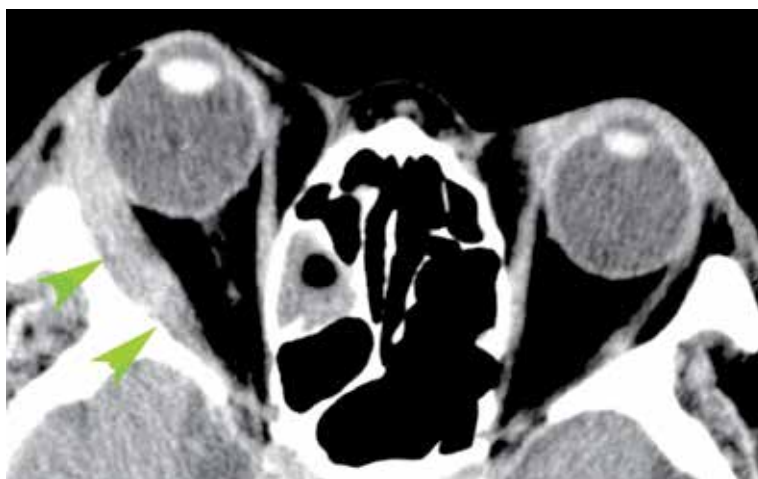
Churg-Strauss syndrome. A 68-year-old man with Churg-Strauss syndrome had periocular pain and restrictions of ocular motility. CT image shows an apparent lateral rectus enlargement.
